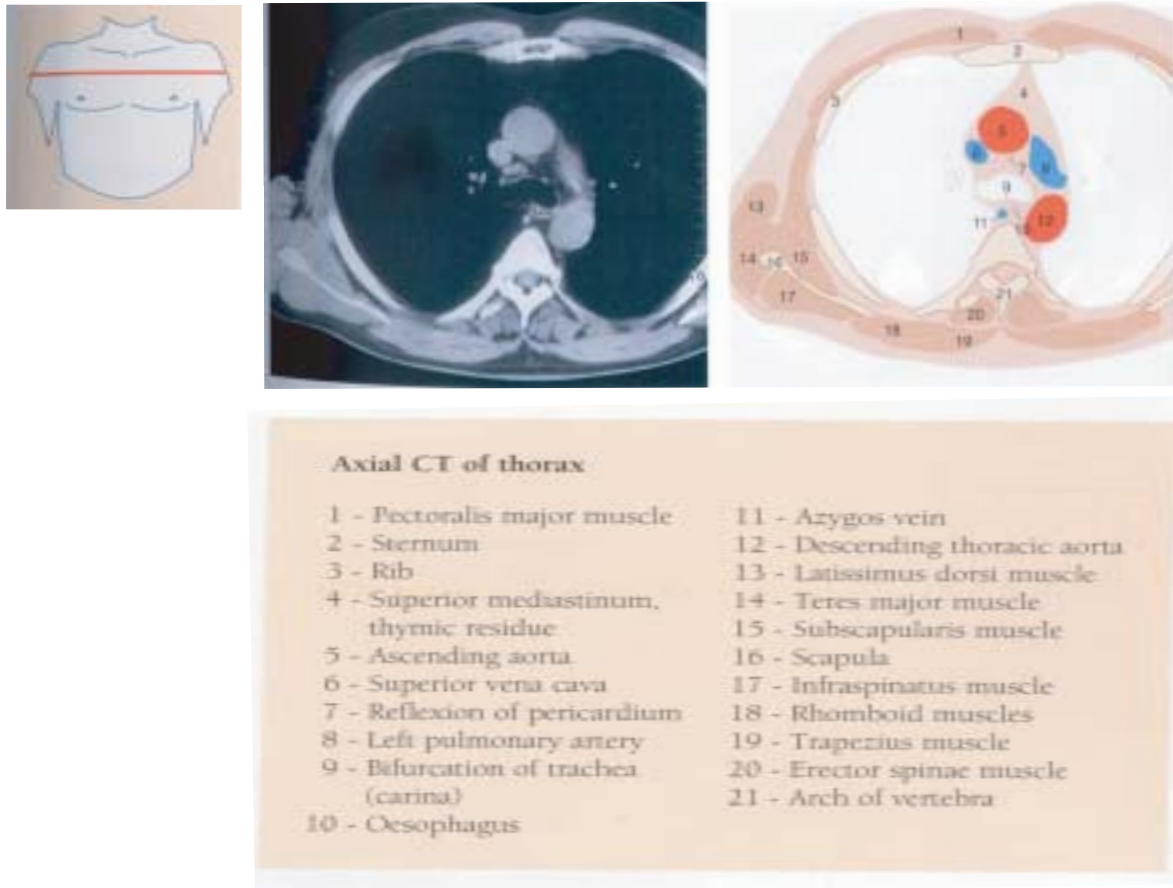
CT scan with references for the anatomy
